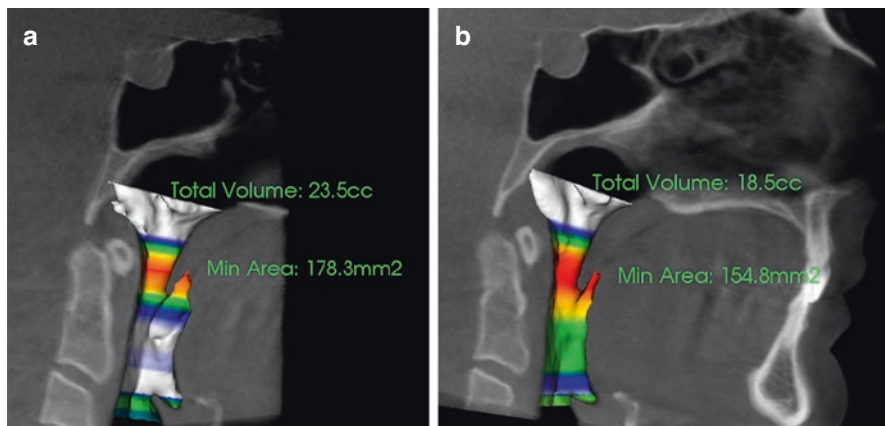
Sagittal CBCT views of the same patient on the same day with two different head positions. (a) in natural head posture shows larger airway dimensions with a more forward head posture than (b) where a head strap was used
